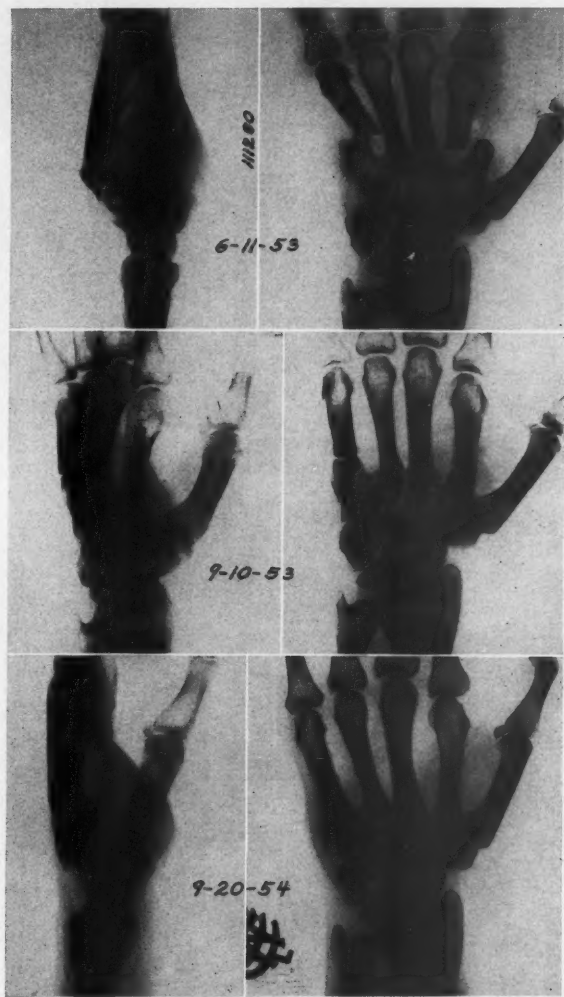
Shows roentgenograms of the hand of a 24 year old man 5 months after a crushing injury. There was nonunion of second, third and fifth metacarpals. Intramedullary bone pegs were used to restore continuity. Note the grafts have completely lost their identity and the fractures have united in anatomic alignment.
